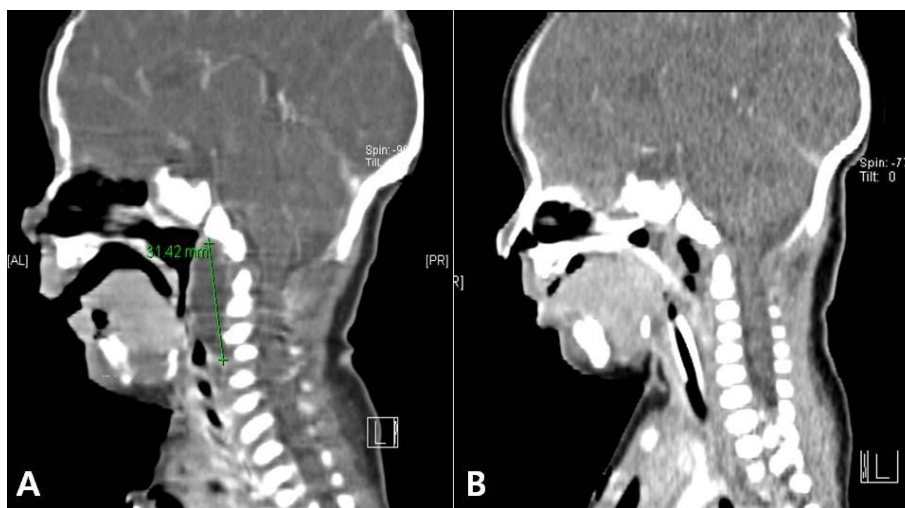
(A) A cervical CT scan shows a large retropharyngeal cystic mass with a low attenuation density, measured at 3.1×2.9×1.1 cm and mainly located from anteroinferior aspect of clivus to anterior portion of C4 body with compression of retropharyngeal and pharyngeal airway. (B) Postoperative cervical CT shows resected lesion of the cystic mass with air shadow and postsurgical fluid collection.
